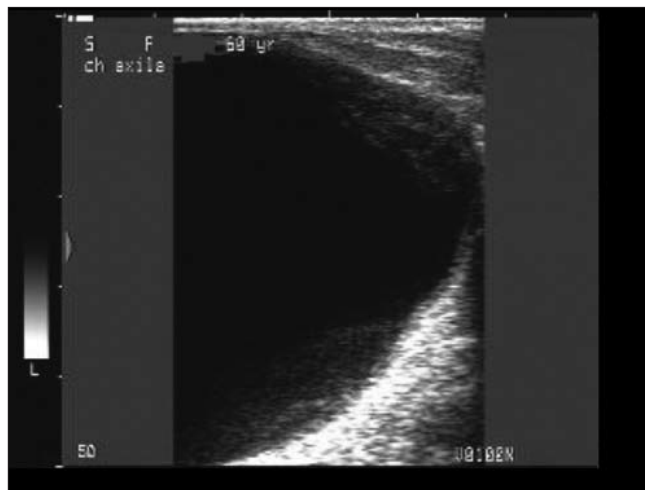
Ultrasound aspect of the cyst
